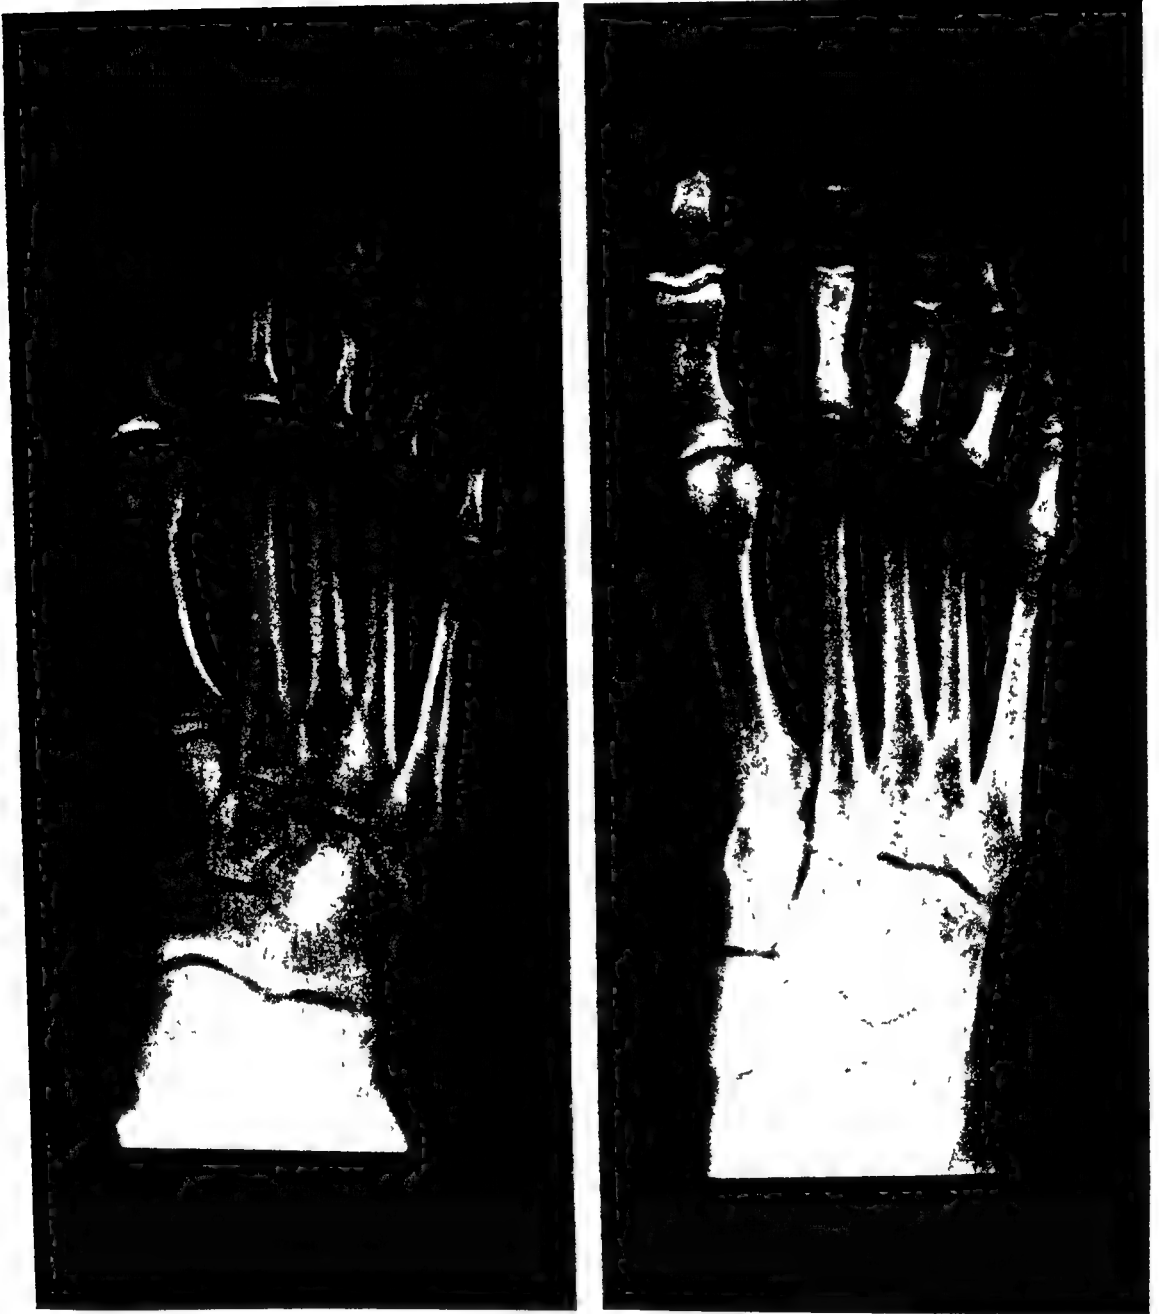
(Left) RADIOGRAPH MADE WITH CENTRAL RAY DIRECTED FROM THE PROPER ANGLE Angle in this case is 15° from vertical in an antero-posterior direction
